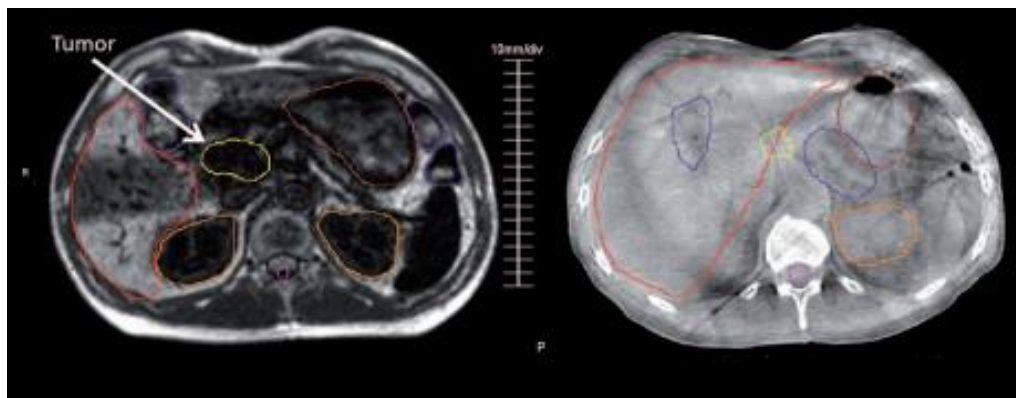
A comparison between abdominal images captured on a 0.35T on-board MR imager (left) and CBCT (right). The low field MRI provides high soft tissue contrast to distinguish between a pancreas tumor and surrounding organs, whereas the CBCT shows insignificant contrast between the two⁹.
